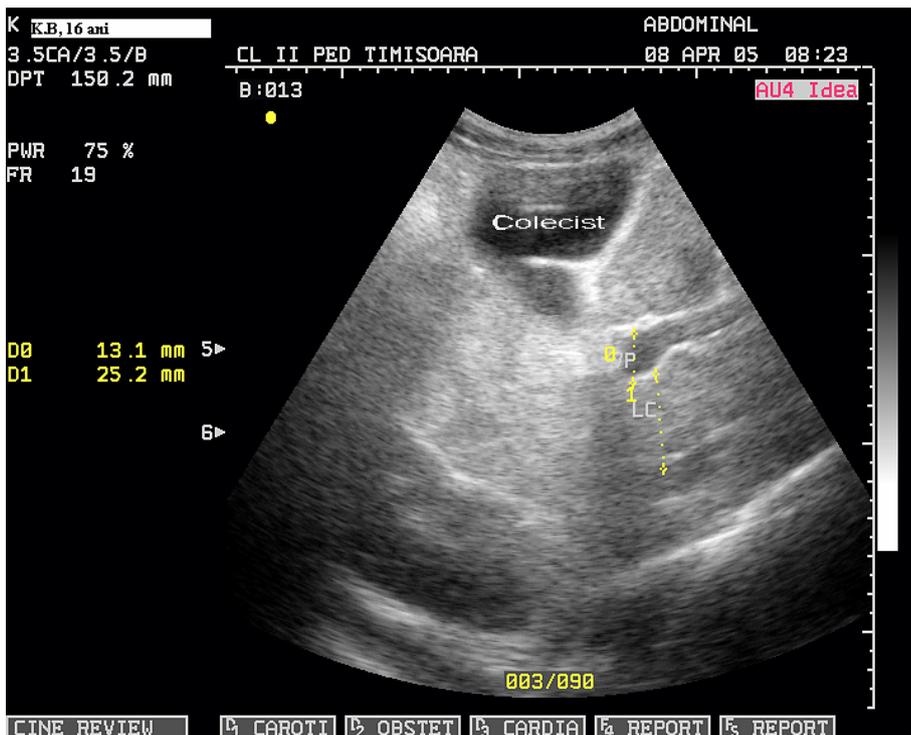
Ultrasound examination.
